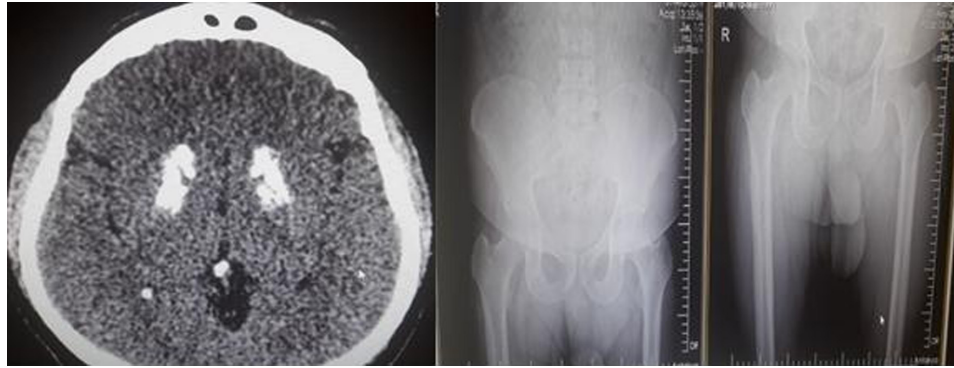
Intracerebral calcifications on computed tomography and diffuse osteosclerosis on long bone radiographs.
